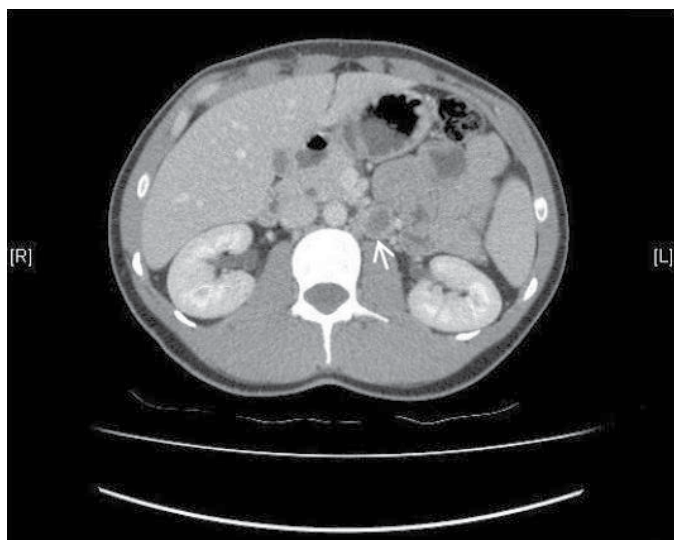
Computed tomography scan of chest, abdomen, pelvis with contrast showing an enlarged left para-aortic lymph node of 22x21 mm (arrow) with a necrotic centre and a few adjacent small volume lymph nodes.
